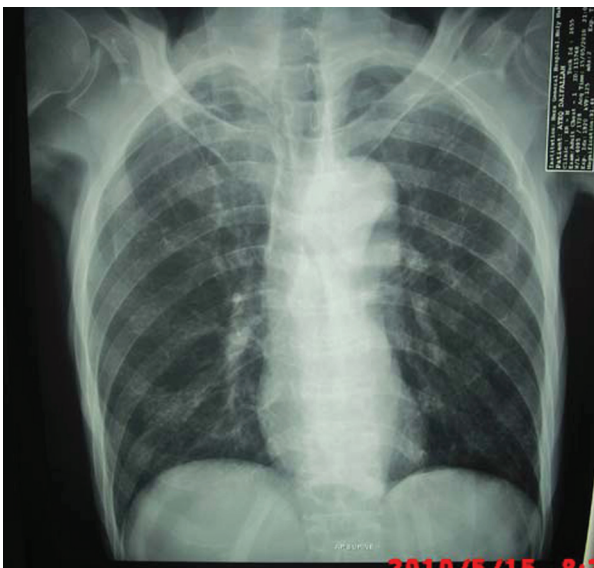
Supine chest x-ray showing no air under the diaphragm.
